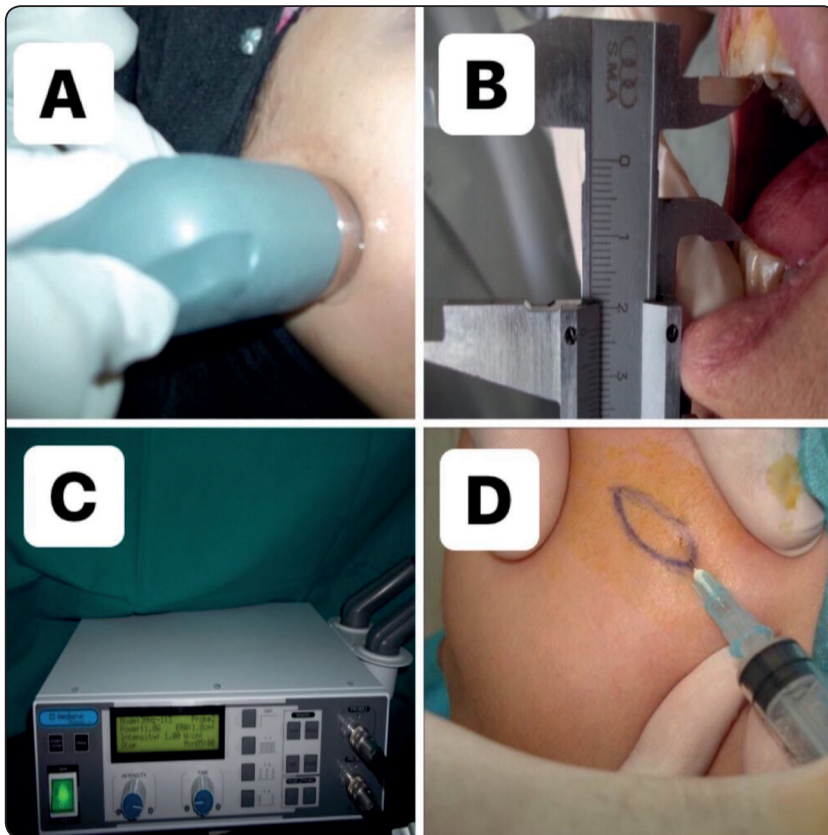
Shows: A, application of ultrasound over trigger point; B, measuring MIO using Vernier caliper; C, Medserve Prosound device of ultrasound; D, dry needle insertion into TrP
